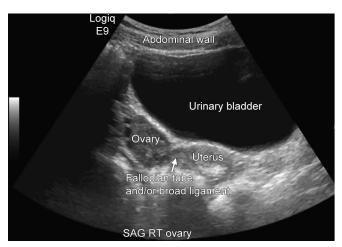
Transabdominal ultrasound of the ovary. Identify urinary bladder, abdominal wall, ovary, uterus and broad ligament/fallopian tube
